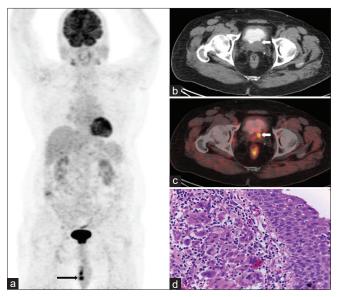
(a) Maximum intensity projection image of 18F-fluorodeoxyglucose positron emission tomography/computed tomography(FDG PET-CT) showing focal FDG uptake in right scrotal region. (b and c) Images showing FDG-avid soft tissue thickening involving left posterolateral wall of the urinary bladder. (d) Biopsy from lesion on the left lateral wall of the bladder showing urothelium on the right with underlying collection of epithelioid histiocytes forming ill-defined granuloma
